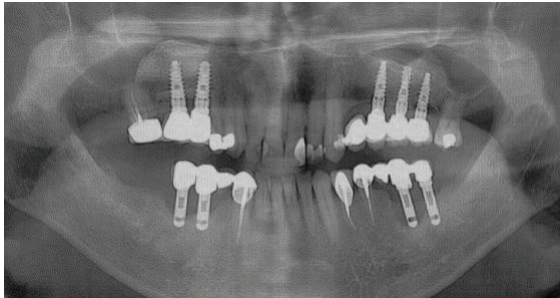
Panoramic radiograph taken 6 months after loading showing well-defined contours of the osteotomized fragment and the augmented sinus floor besides well- osseointegrated implants.
